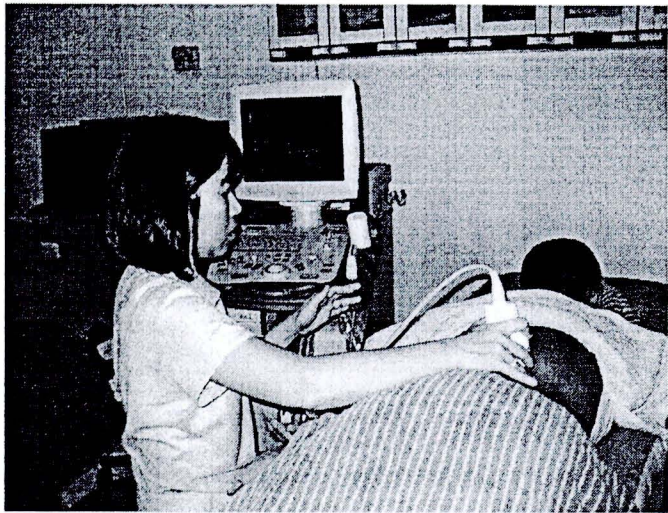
Ultrasound imaging with a 5-MHz curvilinear array was used to measure lumbar multifidus muscles (LM) in a prone lying with a pillow placed under the hip to minimize the lumbar lordosis.
